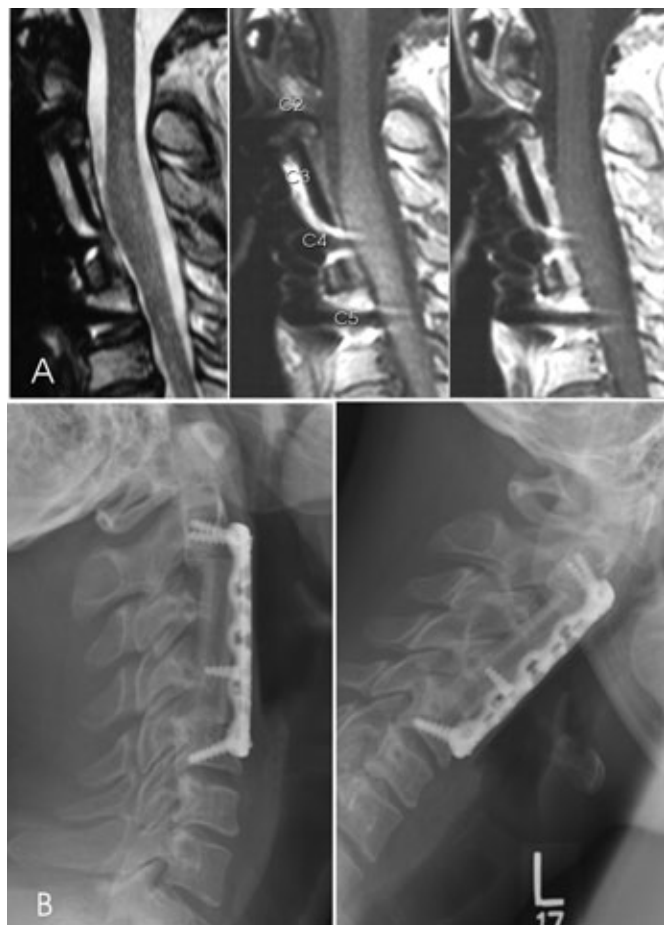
(A) Magnetic resonance sequences six months after surgery. Panels from left to right are T2, T1 and contrast enhanced T1 images. The spinal cord had re-expanded, decompression was complete and there was no evidence of residual tumor. (B) Six month extension and flexion lateral radiographs showed improved lordosis compared to the pre-operative images and stability through the construct spanning C2 to C5.
